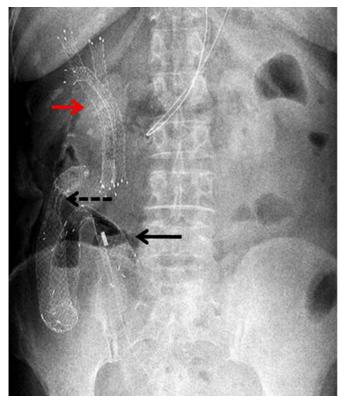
Abdominal X-ray showing biliary metallic stents (red arrow), stents over anastomotic stricture (broken arrow) and terminal ileal stricture (black arrow).
